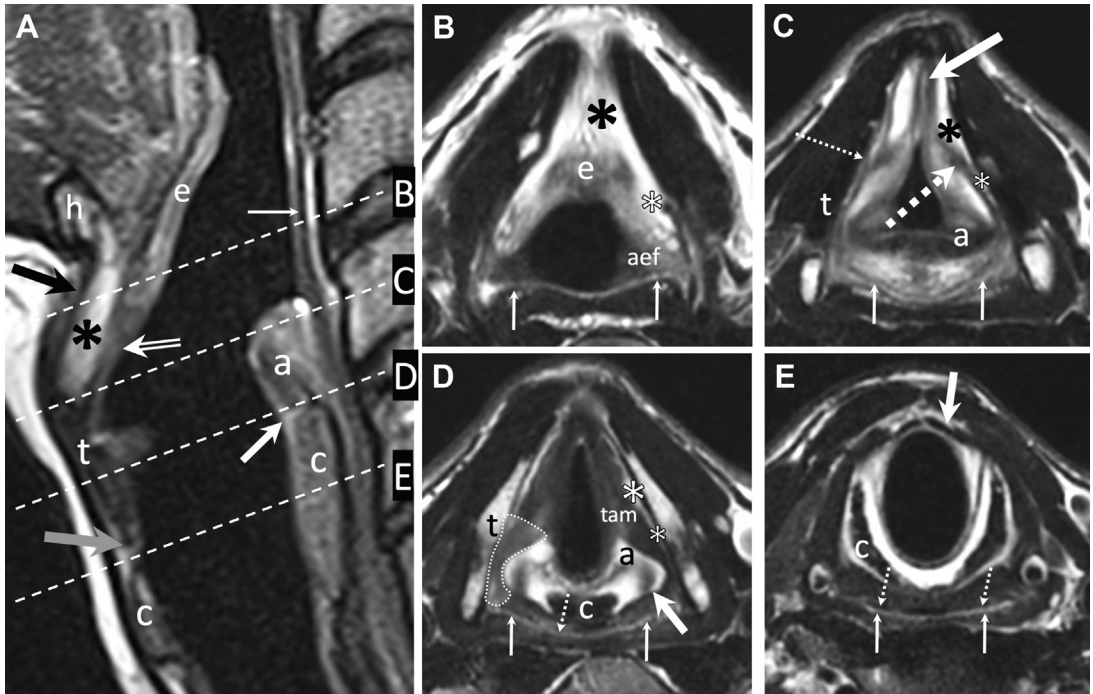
Normal MR imaging anatomy of the larynx and hypopharynx (T2 images without fat saturation). Paramedian sagittal image (A) showing the hyoid bone (h), epiglottis (e), thyroid (t), cricoid (c), and arytenoid (a) cartilages and pre-epiglottic space (asterisk). Thick white arrow indicates the cricoarytenoid joint; thin white arrow indicates the posterior hypopharyngeal wall; black arrow indicates the thyrohyoid membrane; double white arrow indicates the thyroepiglottic ligament located inferiorly to the epiglottis; gray arrow indicates the cricothyroid membrane; and dashed white lines indicate the axial planes of images B to E. (B) Upper supraglottic region. The pre-epiglottic space (black asterisk) is located anteriorly to the epiglottis (e). No clear boundary with the paraglottic space (white asterisk) is present at this level. Aryepiglottic fold (aef), posterior hypopharyngeal wall (thin arrows). (C) Lower supraglottic region (false cord level). The pre-epiglottic space (black asterisk) lies laterally to the thyroepiglottic ligament (thick white arrow) and anteriorly to the paraglottic space (white asterisk). The thyroglottic ligament (thin dashed arrow) separates the pre-epiglottic space from the paraglottic space. Thyroarytenoid and aryepiglottic muscle fibers (thick dashed arrow) merge with the thyroglottic ligament. Arytenoid cartilage (a). Collapsed lumen of the piriform sinuses (thin white arrows). (D) True vocal cord level. The thyroarytenoid muscle (tam) makes up the bulk of the true vocal cords. Paraglottic space (white asterisks). Arytenoid cartilage (a) and cricoid cartilage (c) forming the cricoarytenoid joint (thick arrow). Thyroid cartilage (t). The area surrounded by the thin dashed contours is the TCAS. Dashed arrow points at the retrocricoid region of the hypopharynx and thin solid arrows point at the posterior hypopharyngeal wall. Note that the posterior parapharyngeal space is bordered posteriorly by the piriform sinuses. (E) Subglottic region. Cricoid cartilage (c). Cricothyroid membrane (thick arrow). Dashed arrows point at the retrocricoid region of the hypopharynx and solid thin arrows point at the posterior hypopharyngeal wall.
